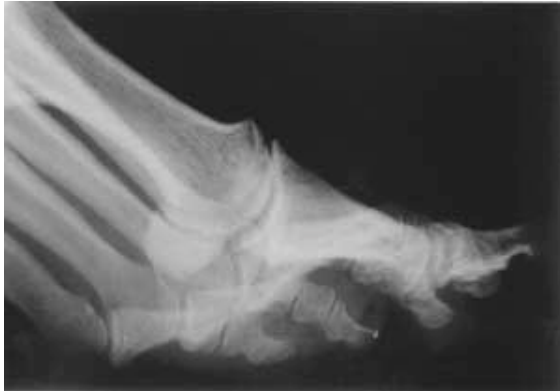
Stage II hallux rigidus: b) On the lateral radiograph, joint space narrowing is most pronounced at the dorsal segment of the joint. The width of the plantar joint space is still preserved. Beginning osteophyte formation is noted at the dorsal aspect of the first metatarsal head.
